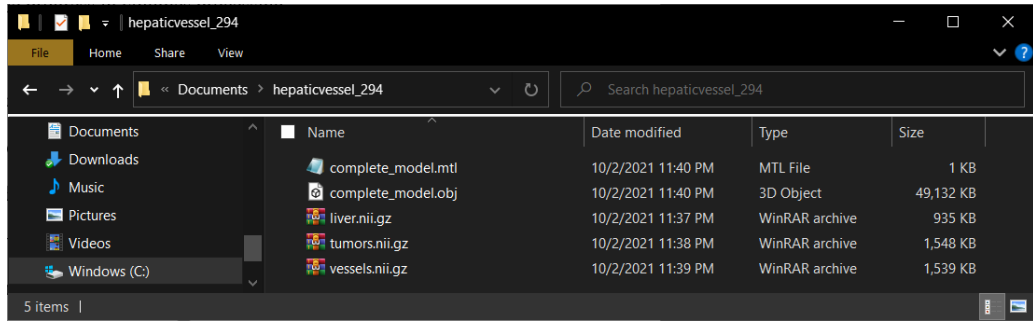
Resulting files for a particular CT scan/volume.
